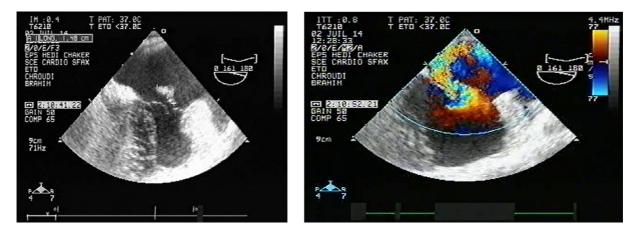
Transesophageal echocardiography revealing a large, mobile and pedunculated vegetation measuring 15 mm \times 10 mm attached to the anterior tricuspid valve with severe regurgitation.
